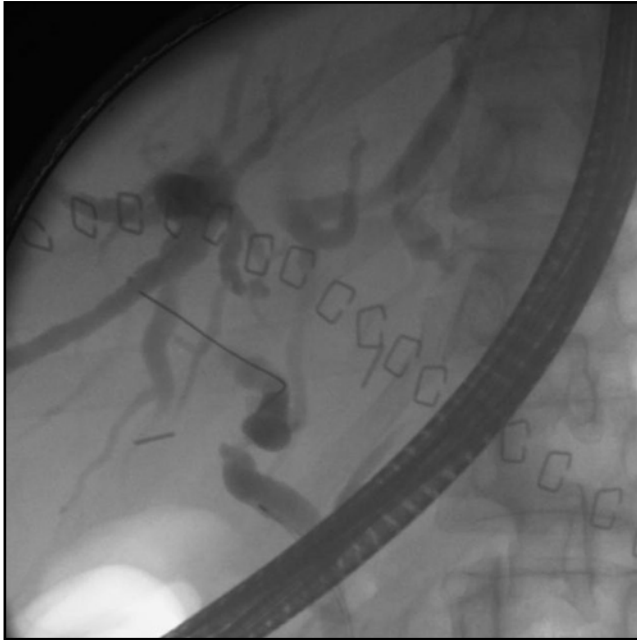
Radiographic image of anastomotic stricture.
